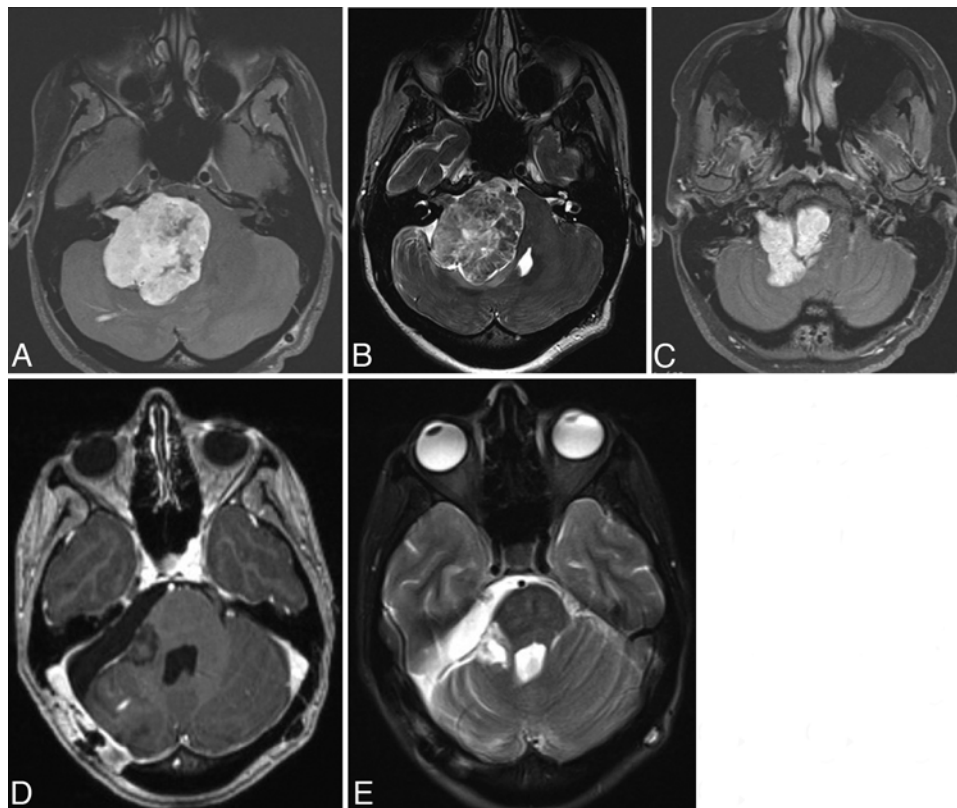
Representative axial MR images from the senior author's patient, demonstrating the extent of brainstem compression (A), presence of minimal brainstem edema (B), and tumor within the jugular foramen (C). Postoperative images (D and E) reveal gross-total removal of the mass. Images A, C, and D are T1-weighted with contrast enhancement, images B and E are T2-weighted.
